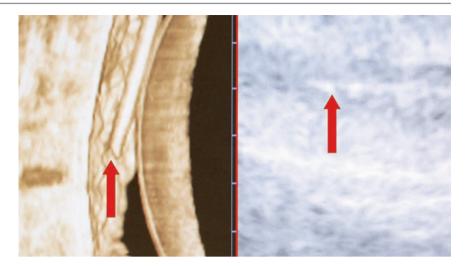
3D needle ultrasound and needle visibility. This is a 3D ultrasound probe. Currently 3D ultrasound probes are larger than their 2D counterparts. However, newer, smaller 3D ultrasound probes are in development
